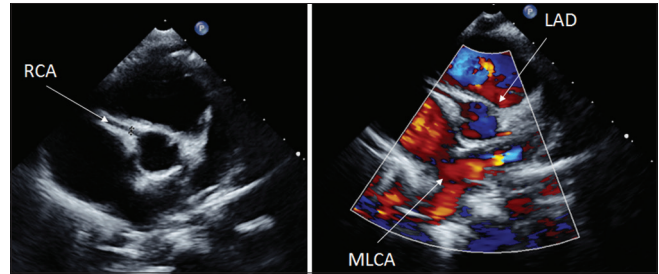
Echocardiogram finding in the patient with normal coronaries vessels dimension. Normal coronary arteries with normal z-score: (1) Main left coronary artery (MLCA): 2.7 mm. (2) Left anterior descending artery (LAD): 1.9 mm. (3) Right coronary artery (RCA): 2.3 mm
